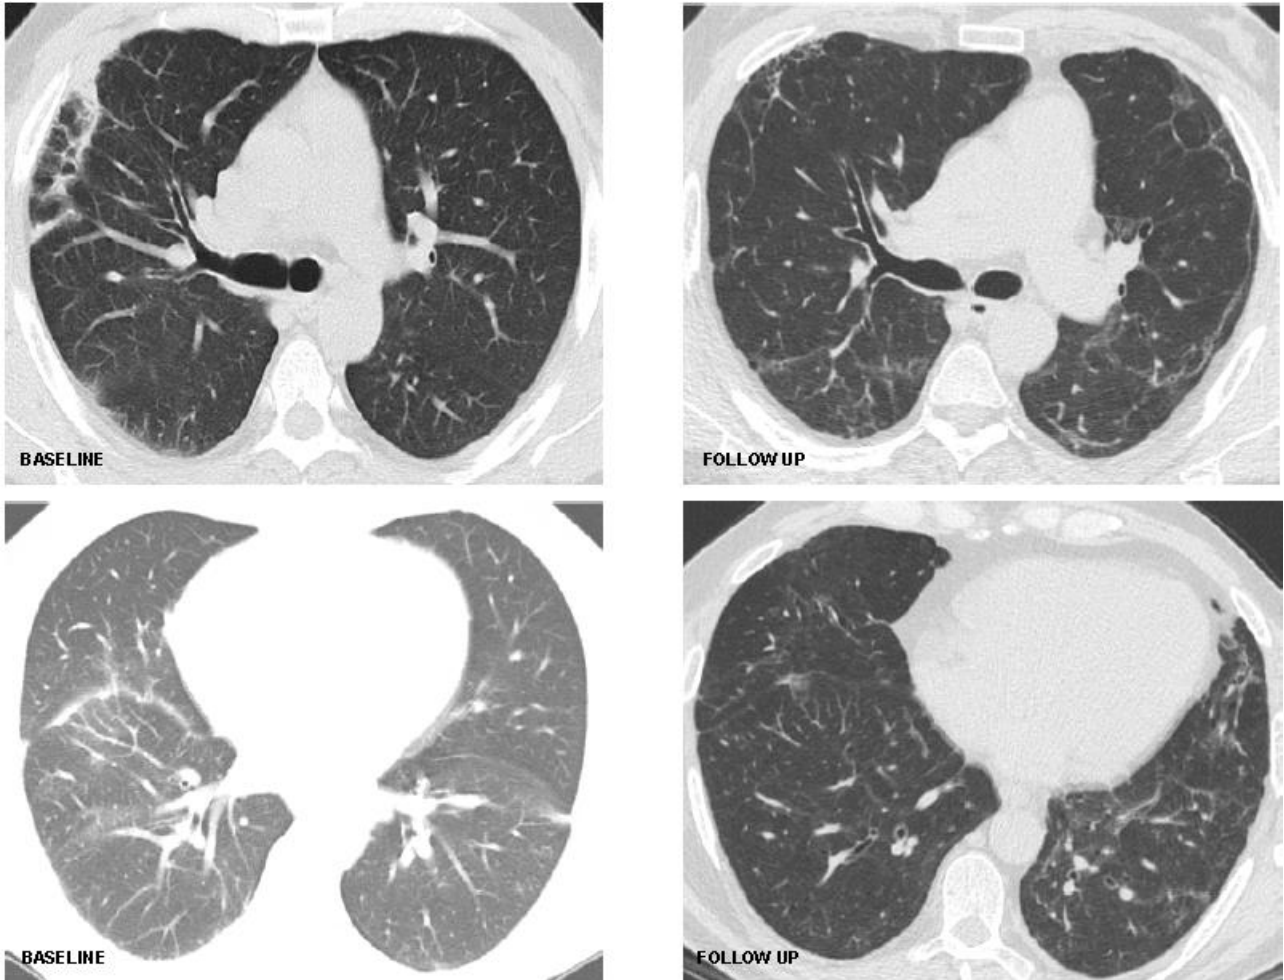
Patient 1. Baseline and follow-up images at the level of aortic arch (upper) and left atrium (lower). Initial CT findings include areas of ground glass opacities (GGO) with extensive crazy paving in the lower lobes associated with some cysts (LIP pattern). 20 months later follow up scan show minimal diffuse GGO and subpleural reticulations with rare traction bronchiolectasis and enlargement of some cysts.
